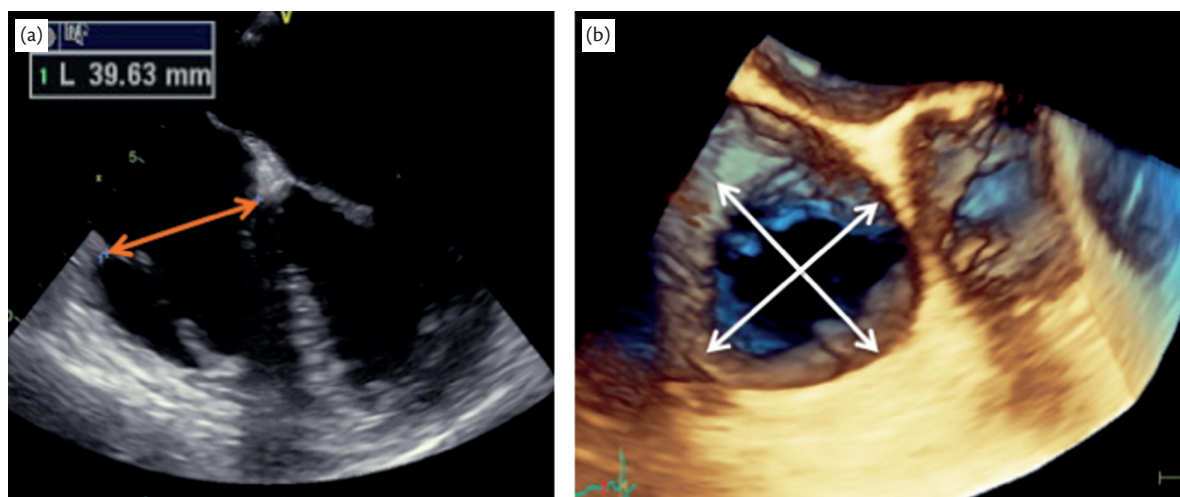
Two-dimensional (a) and three-dimensional (b) echocardiographic assessment of the tricuspid annulus showing a non-circular shape.
